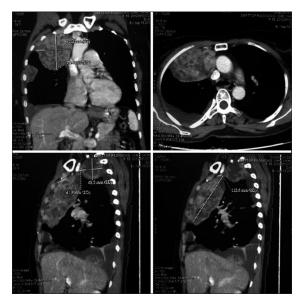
Contrast enhanced computed tomography chest shows multiple pleural and diaphragm based masses on right side
